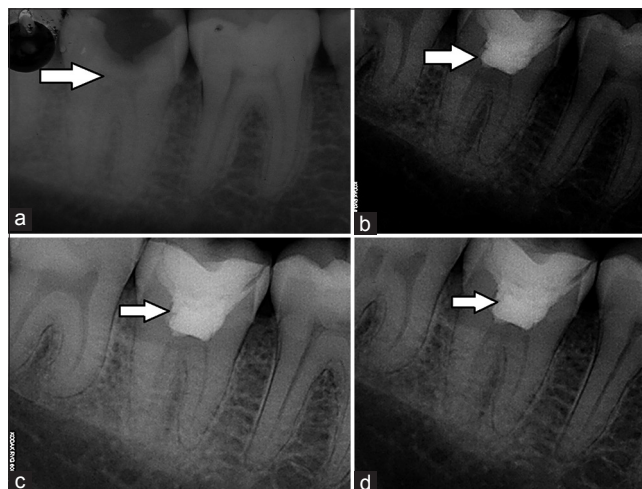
Radiographic evaluation of a case with mineral trioxide aggregate pulpotomy (tooth #47). (a) Preoperative radiograph. (b) Immediate postoperative radiograph after performing pulpotomy. (c) Six months follow-up radiograph. (d) One-year follow-up radiograph
